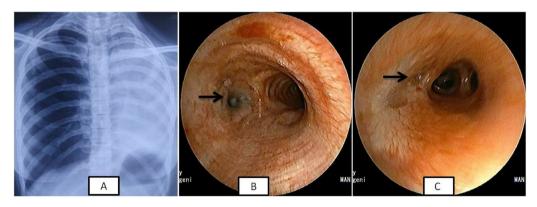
Chest X-ray showing complete collapse of left lung (1A), bronchoscopy image of the same patient showing circumferential stenosis of left main bronchus (1B) and complete stenosis of opening of right middle lobe bronchus (1C). The arrows point towards the stenotic lesions.
